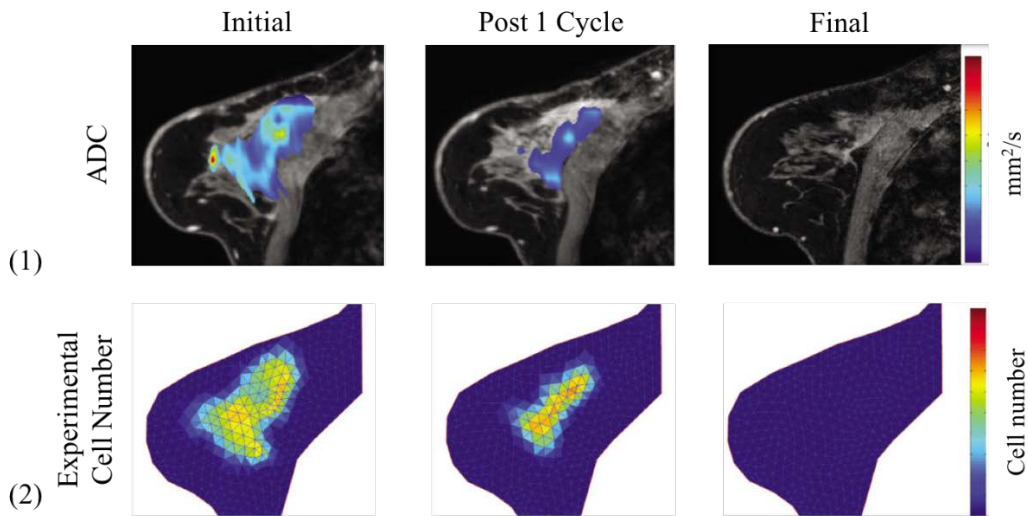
(1) Apparent Diffusion Coefficient (ADC) maps using diffusion weighted (DW) MRI overlaid on T1 structural image. (2) Converted cell number distribution based on image series in (1). Figure is extracted from [64] with journal's permission.
